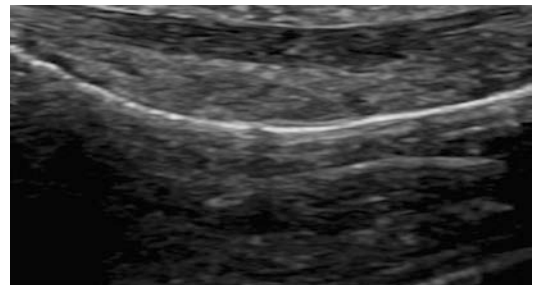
Sonography under provocation, massive bowstringing over the A4 pulley
